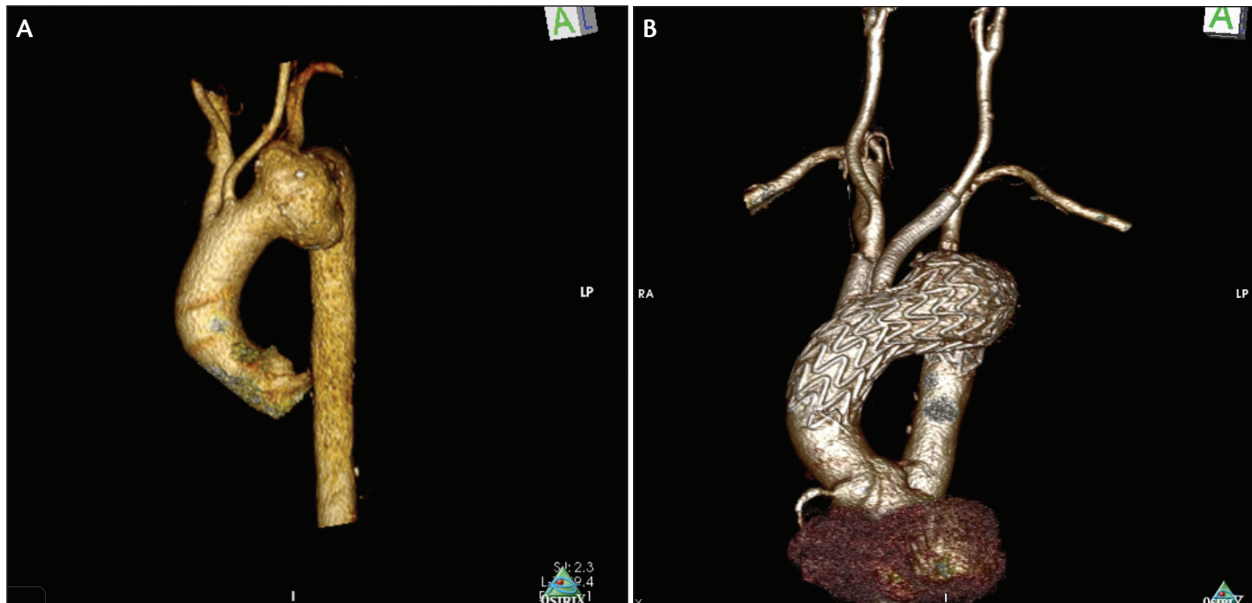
Total endovascular aortic arch replacement using the sandwich technique. CTA of an aortic arch with no adequate proximal landing zone (zone 0) (A). Six-month CTA follow-up (B).
